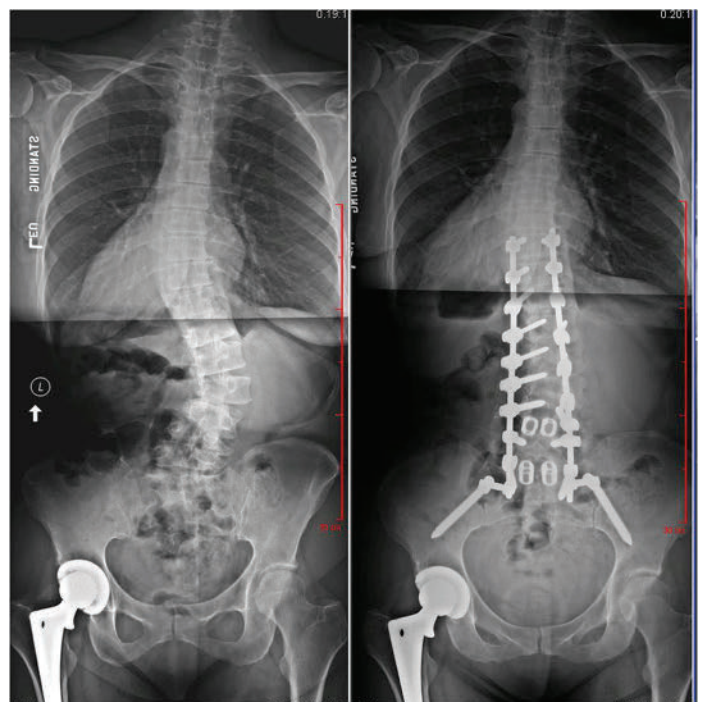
X-rays taken before and after scoliosis correction surgery.
